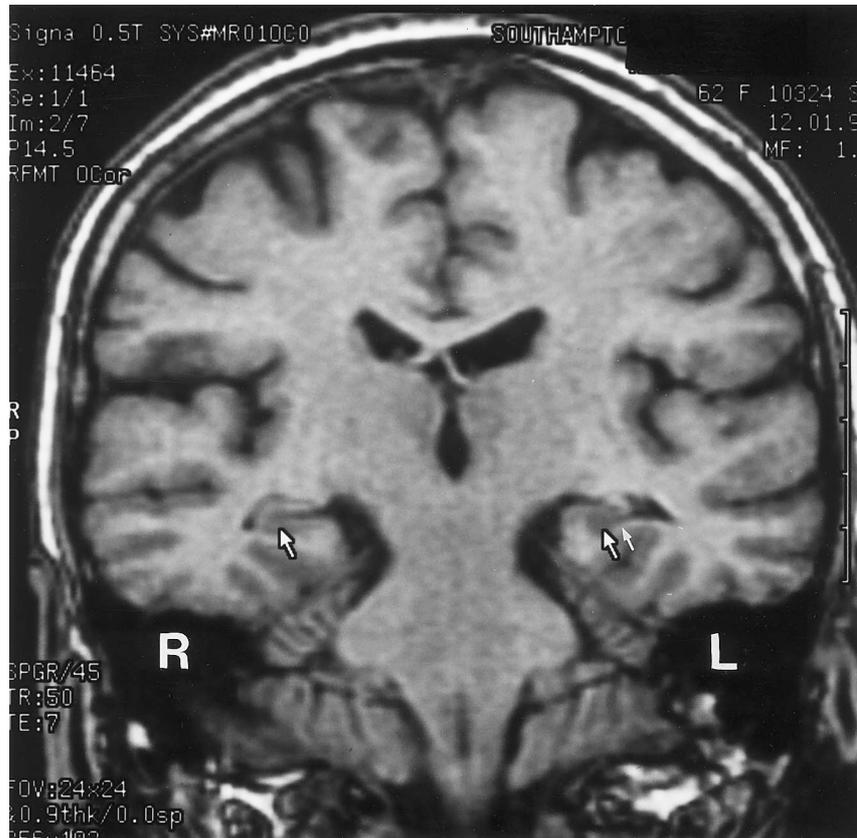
Left hippocampal abnormality (twin arrows) as evident on coronal view of MR imaging sequence, compared to the normal right hippocampus (single arrow).
